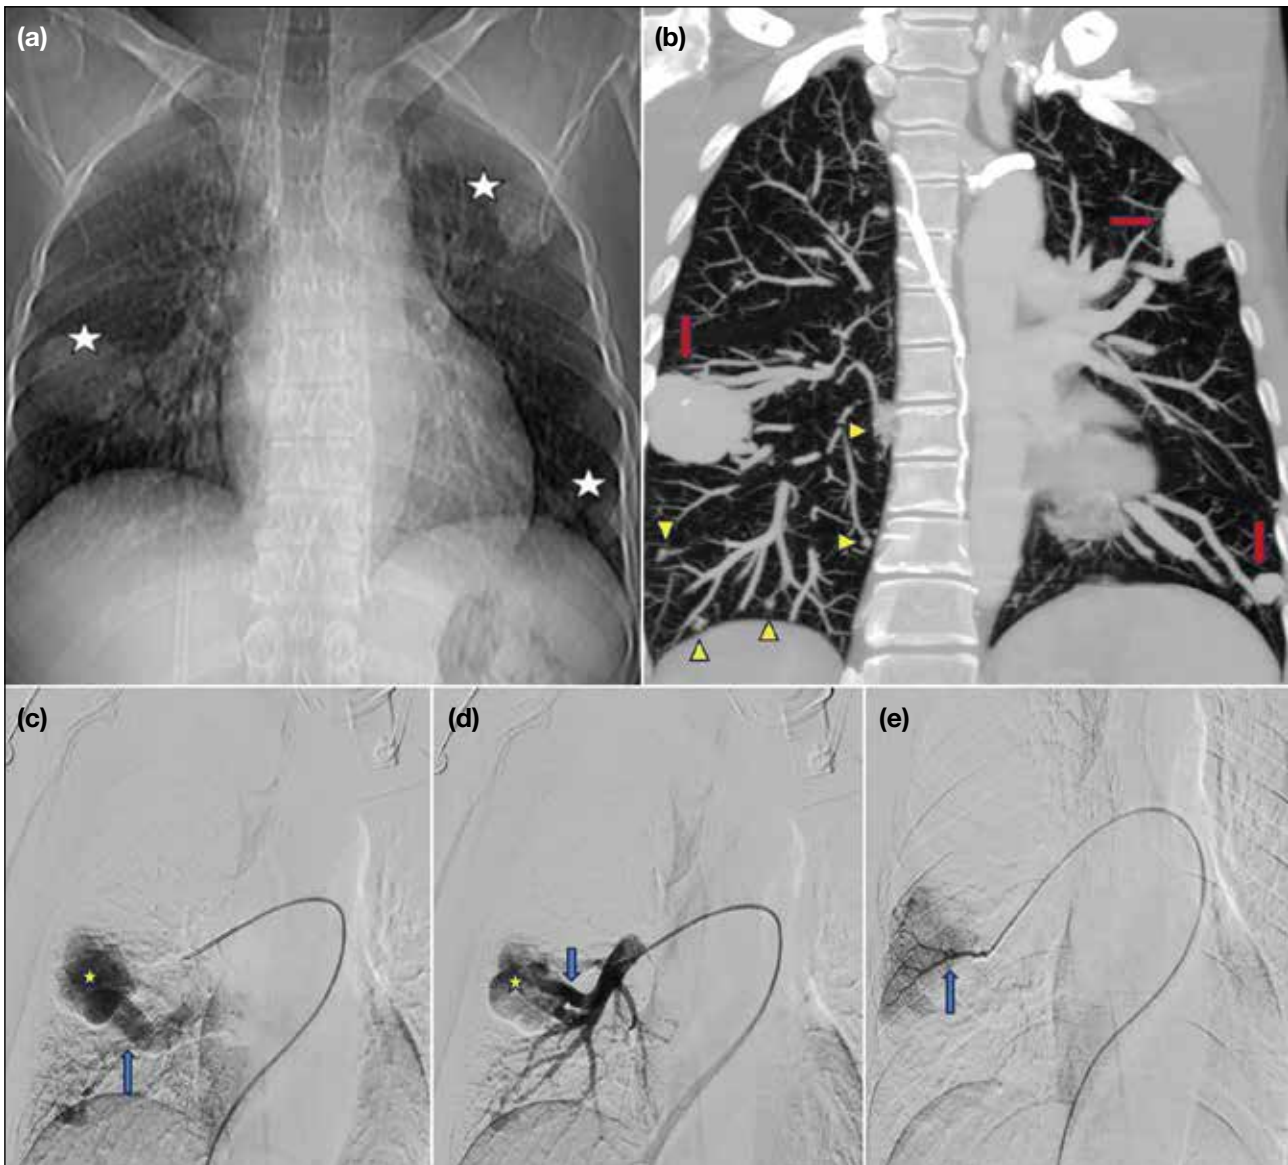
Case 3. (a) Chest radiograph showing multiple homogenous mass lesions (stars) seen in the right lower zone and left upper and lower zones. (b) Reformatted coronal maximum intensity projection image showing multiple arteriovenous malformations (AVMs) involving the antero-basal segment of the right lower lobe, apicoposterior segment of the left upper lobe, and the lateral basal segment of the left lobe (red arrows). Multiple tiny AVMs are seen in the right lower lobes (yellow arrowheads). (c) Pre-procedure digital subtraction angiography image of the right lung showing pulmonary AVM (star) with supply from the basal segmental arteries (blue arrow). (d) The AVM nidus (star) was progressively embolised using micro coils with 60% glue and subsequent opacification was seen. Blue arrow indicates vascular supply to the nidus from the basal segmental arteries. (e) Post-procedure angiogram shows complete exclusion of AVM from circulation (blue arrow).
